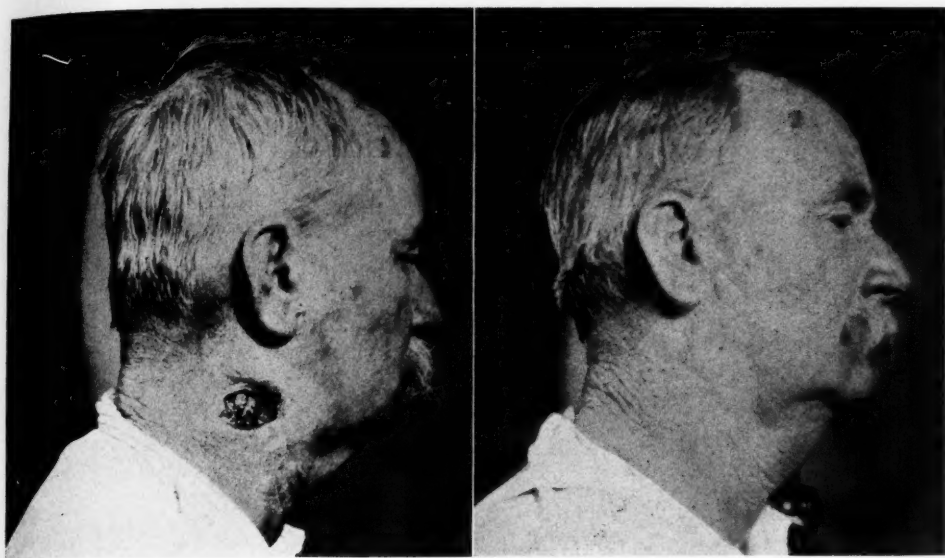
Farmer, age 59. Was first seen February 22, 1919. Family history negative. In 1912 a scaly patch appeared on right side of neck. This was treated with some kind of plaster. In 1917, a new lesion appeared on site of former growth and later broke down and ulcerated. At time of his visit there was a deep ulcer, with hard, indurated edges that rolled inward (Fig. 4A, left). Diagnosis was in question but since there was no metastasis growth was probably a basal cell carcinoma. Six double erythema doses of X-rays through a cone one and one-half inches in diameter caused lesion to heal (Fig. 4B, right).
